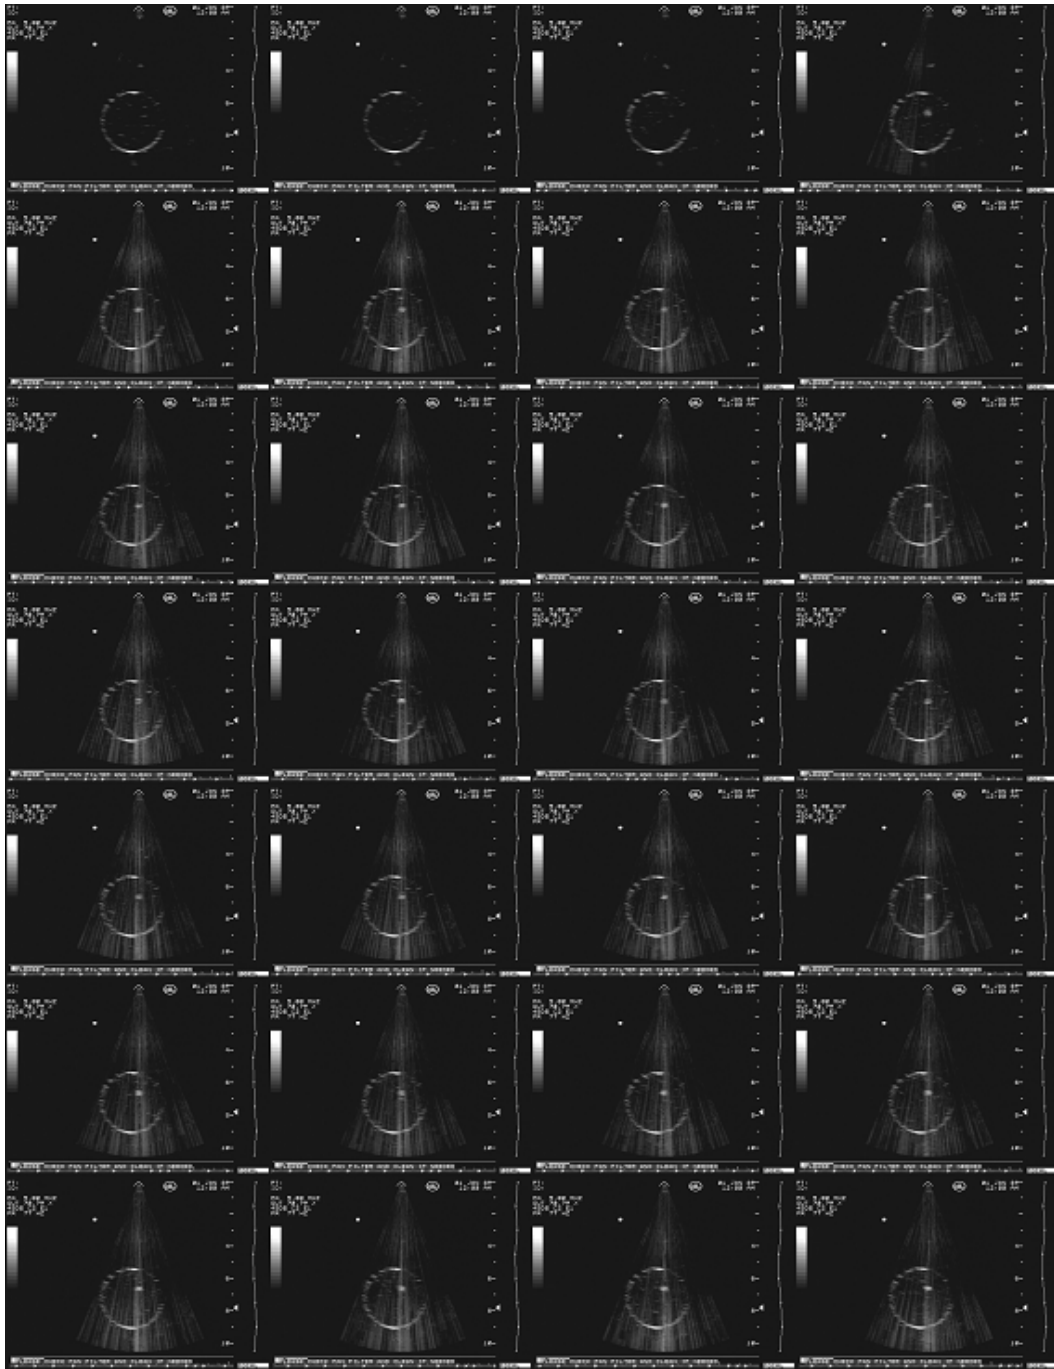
PVA under ultrasound excitation.
